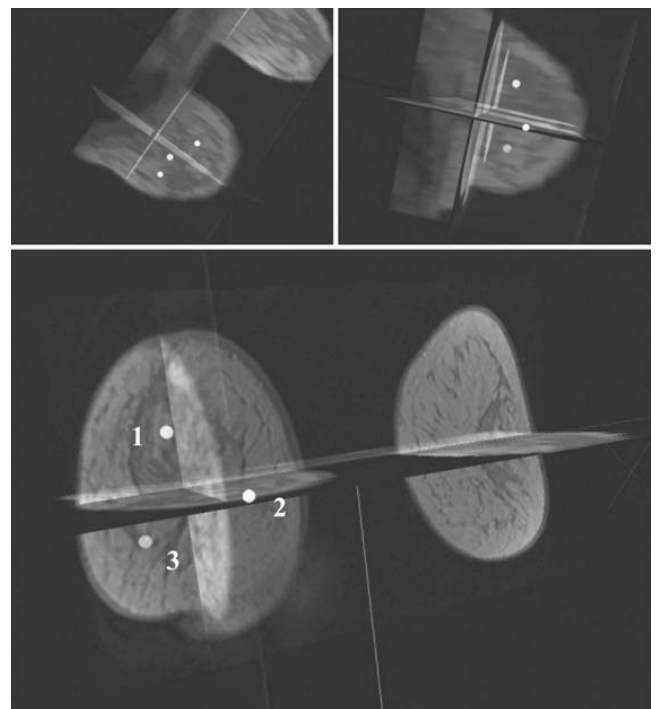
3D visualizations of the location of the three calcification clusters in the reference frame of the MRI volume (labelled according to the previous figure).
